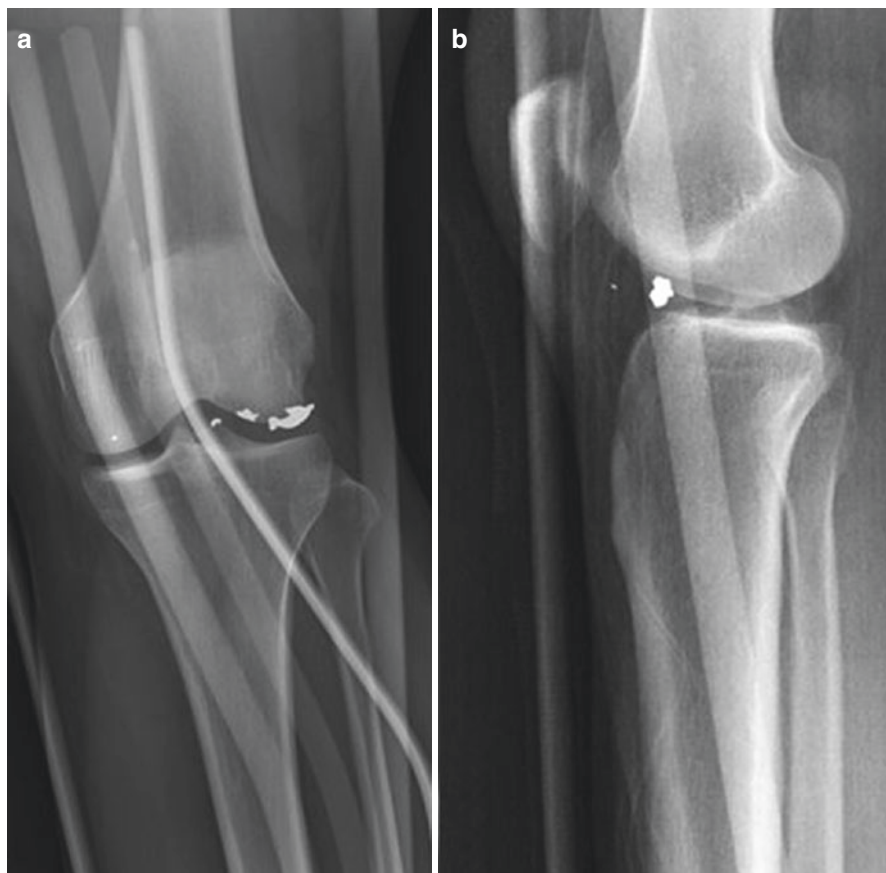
AP (a) and Lateral (b) X-rays are shown demonstrating intra-articular fragments following a low-velocity gunshot wound
